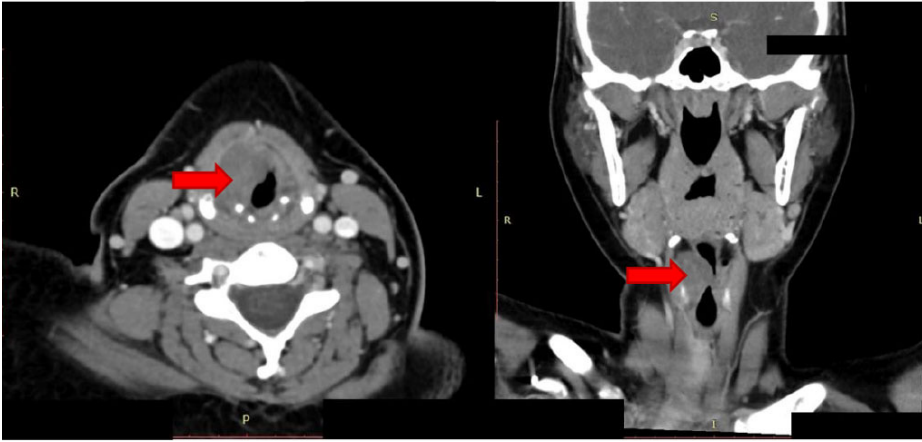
and 2B. Computed tomography (CT) revealed the presence of a homogenous, hypodense mass at the level of the right vocal cord measuring about 2x2cm (red arrow).
